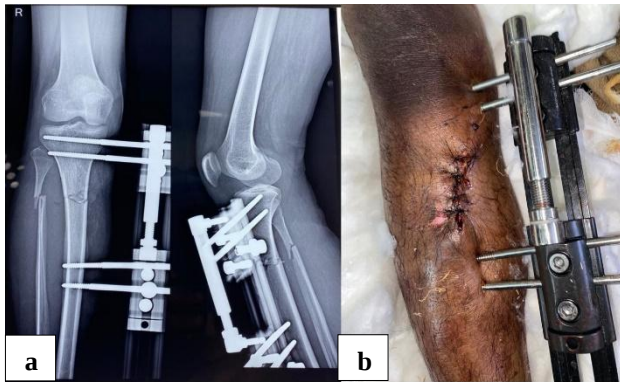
(a and b): Post-operative X-ray and clinical photo.
